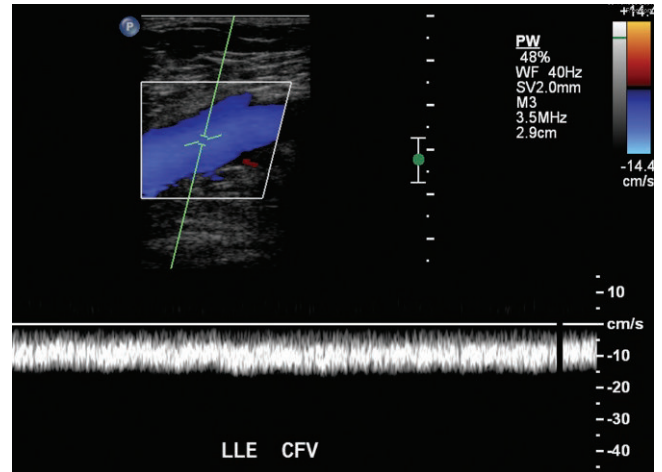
In different patient with bilateral leg swelling, spectral Doppler of the common femoral vein is blunted and nearly continuous.
